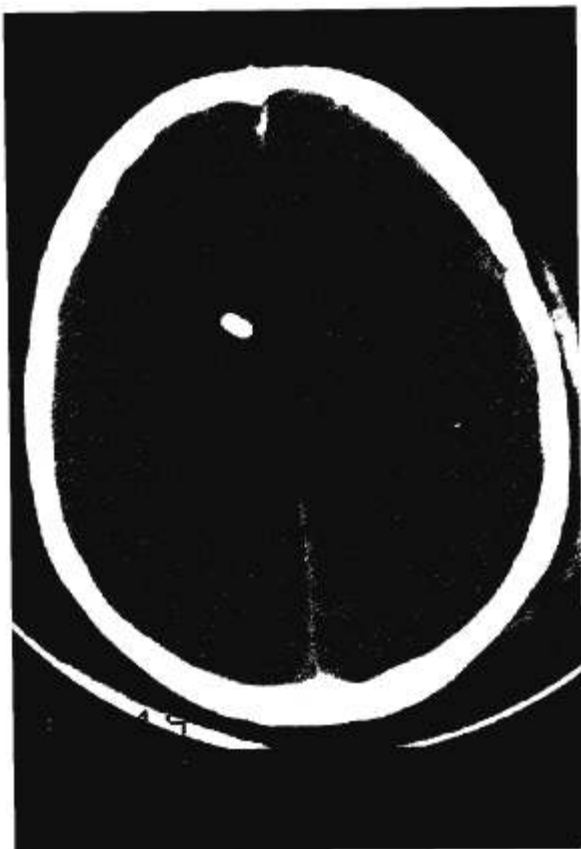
CT brain scan taken 3 days after the surgical procedure shows bilateral multifocal ischemic areas.
